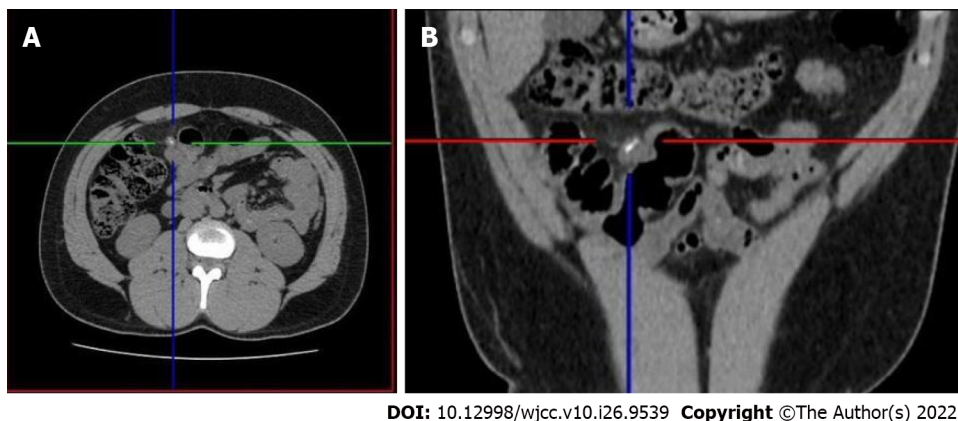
Computed tomography. A: Axial; B: Coronal. Pneumoperitoneum and a hyperdense image in the ileal wall.
